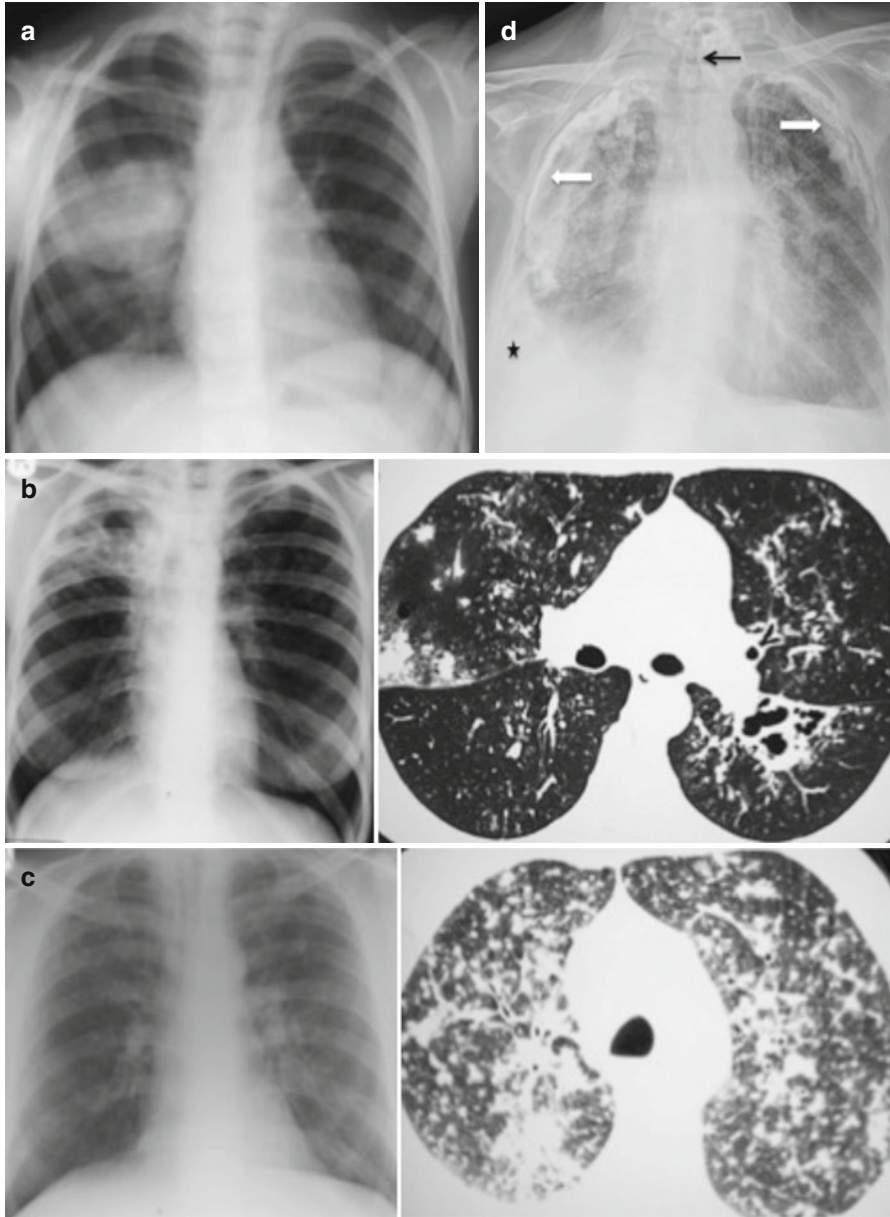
(a–d) Series of images demonstrating various forms of TB. (a) Dense consolidation in right mid zone with bulky right hilum in primary disease. (b) Cavitating lesions in right upper and left lower lobes, the latter has developed on the CT taken 2 weeks after the CXR in post primary disease. (c) Miliary TB characterised by innumerable randomly distributed micronodules in both lungs. (d) A 75 year-old female patient with respiratory failure. There is a tracheostomy (*black arrow*) and moderate right pleural effusion (*black star*) on a background of marked bilateral pleural calcifications (*white block arrows*), a chronic sequel of TB empyema
